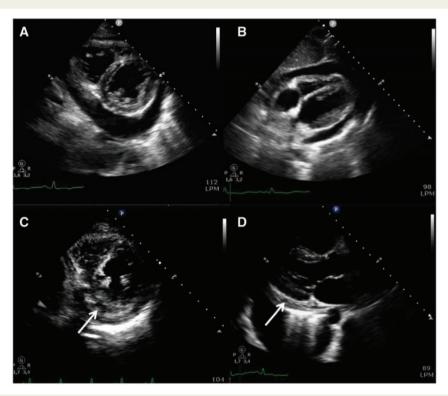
Transthoracic echocardiogram. (A and B) Short axis and subcostal view at admission. (C and D) Short- and long-axis view after 12 days of treatment showing fibrin content (arrow) in the pericardial space and left pleural effusion.
